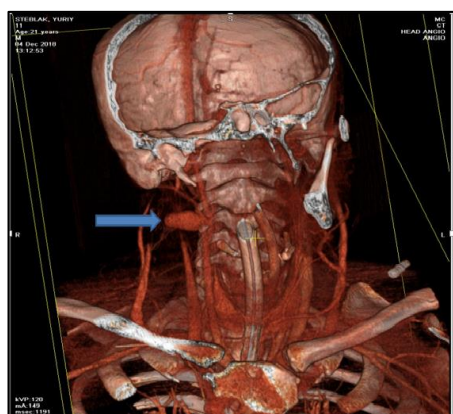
Head and neck CT with contrast enhancement. 3d reconstruction, frontal view
